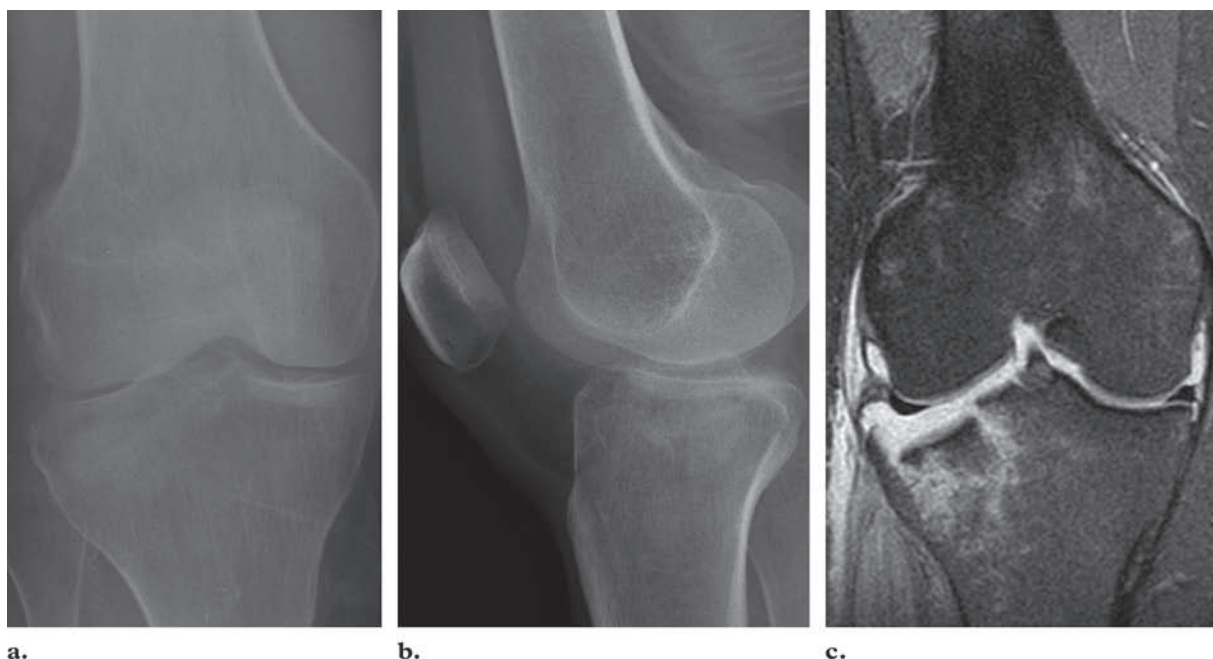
Type IIIA fracture in a 31-year-old woman who was in a motor vehicle accident. (a, b) Posteroanterior (a) and lateral (b) radiographs show ill-defined increased opacity at the subarticular lateral tibial plateau and a large joint effusion. These findings are suggestive of a depressed fracture of the lateral tibial plateau, a Schatzker type IIIA fracture. (c) Coronal T2-weighted MR image shows depression of the tibial articular cartilage; the depression is more extensive than indicated on the radiographs. A possible injury to the suspensory ligament of the lateral meniscus is also suggested.
